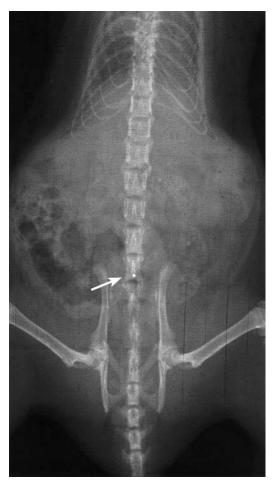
Radiograph demonstrating the location of the hole (*arrow*). The landmarking was made by inserting a small radiopaque fragment into a drilled hole.
